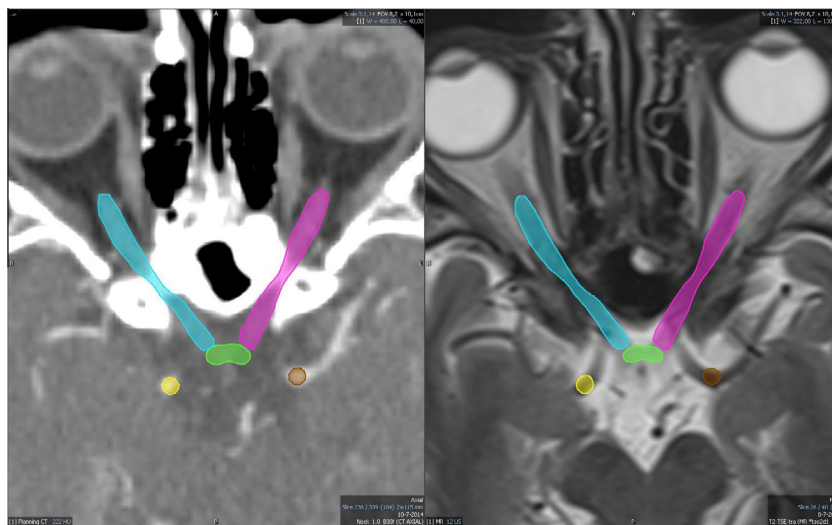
Delineation of the optic nerves (blue and purple), optic chiasm (green) and carotid arteries (yellow and brown) on CT (left) and MRI-T2 (right).
